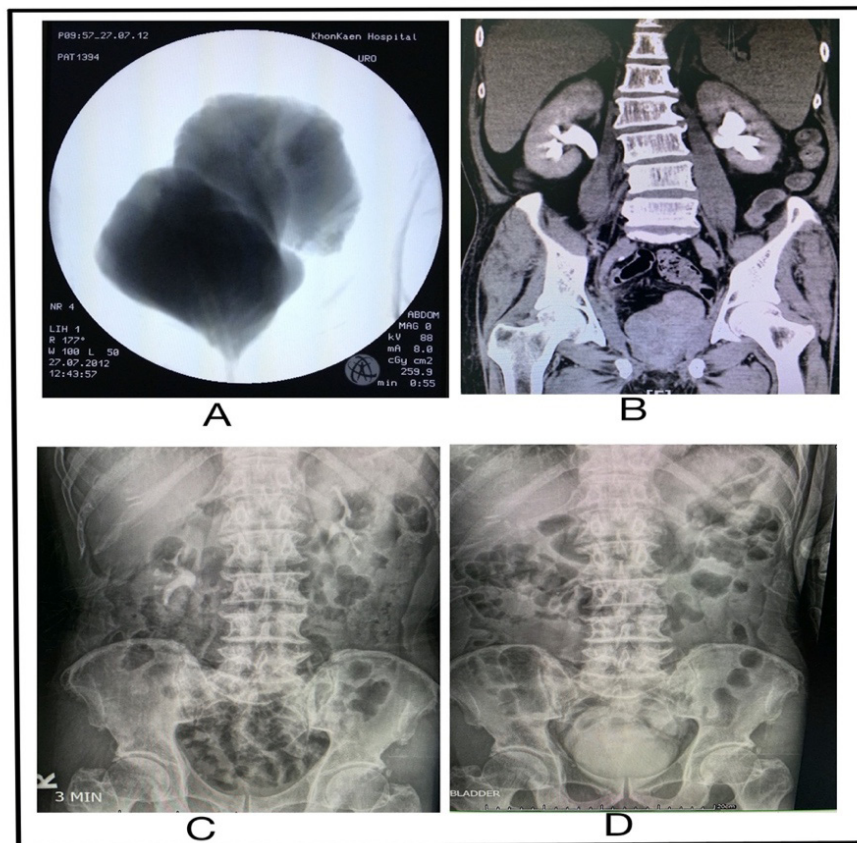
A: VCUG showing evaluation of VUR and bladder capacity at 12 months. B: CT scan showing kidney function 6 months after surgery. C and D, IVP showing kidney function and y pouch neobladder shape
